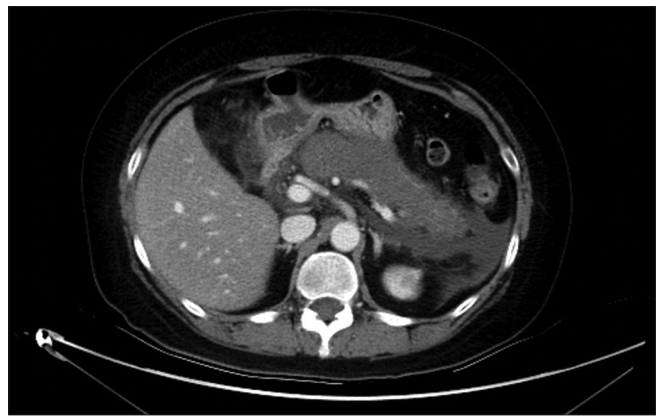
Image of acute pancreatitis. Three years after starting the combination therapy, the patient presented to our emergency room with complaints of epigastric pain and cold sweating. Laboratory tests revealed an elevated lipase level (>6000 U/L), and computed tomography showed acute necrotizing pancreatitis
